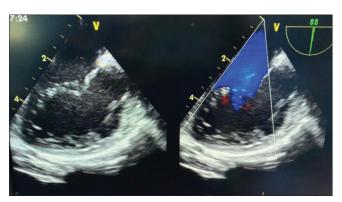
Transesophageal echocardiogram showing the disappearance of the mass
